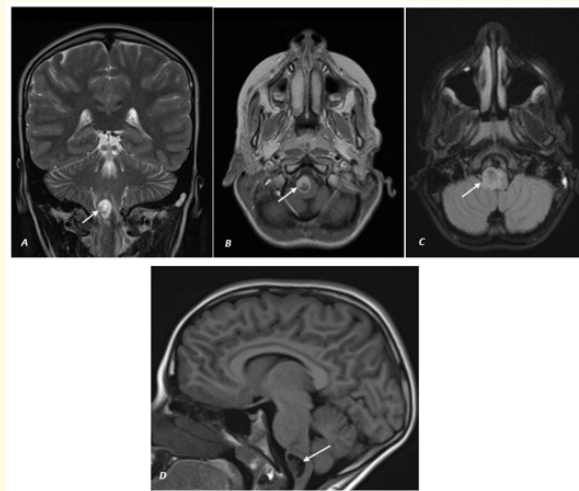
Brain MRI showing the focal medullary lesion: A) Coronal T2-weighted image showing a well-defined, oval-shaped lesion within the medulla oblongata with high T2 signal intensity (Arrow); B) Axial FLAIR image highlighting the hyperintense cystic-solid nature of the mass (Arrow); C) Axial post-contrast T1-weighted image demonstrating heterogeneous enhancement of the solid mural component (Arrow); D) Sagittal T1-weighted image displaying the low T1 signal intensity of the predominantly cystic lesion within the medulla (Arrow).
